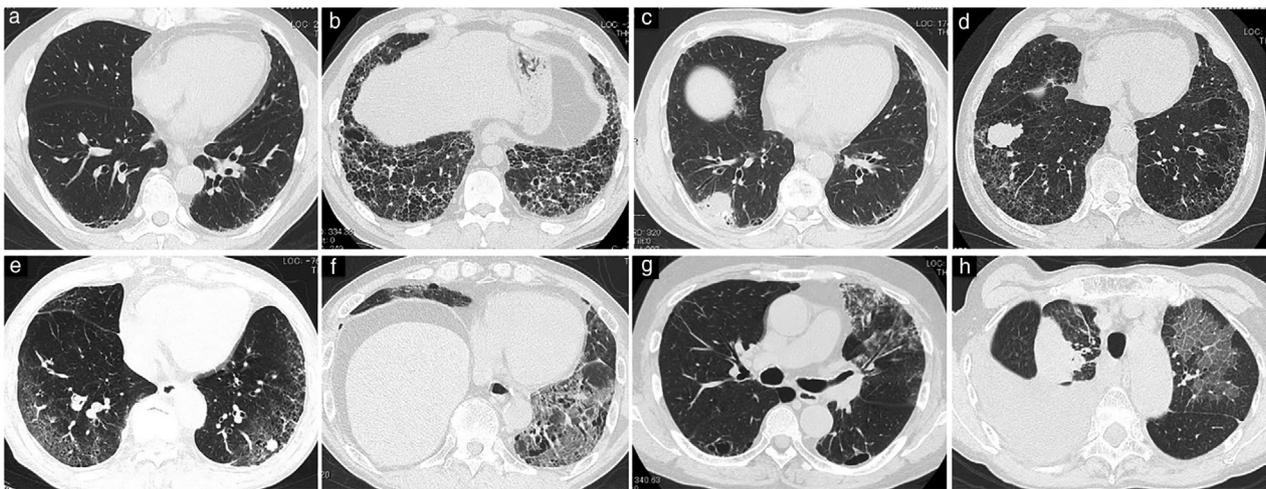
High-resolution computed tomography (HRCT) image of the chest. (a) Pretreatment chest HRCT image showing very slight reticular shading with subpleural and basal lung predominance (indeterminate for usual interstitial pneumonia [I-UIP] pattern). (b) Pretreatment chest HRCT image showing honeycomb lung with subpleural and basal lung predominance (usual interstitial pneumonia [UIP]). (c) Pretreatment chest HRCT image showing reticular lesions and traction bronchiectasis with subpleural and basal lung predominance (probable UIP). (d) Pretreatment chest HRCT image showing predominant ground-glass opacities (GGOs) with subpleural and basal lung predominance (alternative diagnosis). (e) Pretreatment chest HRCT image showing predominant GGOs with subpleural and basal lung predominance (alternative diagnosis). (f) Pretreatment chest HRCT image showing predominant GGOs with subpleural and basal lung predominance (alternative diagnosis). (g) Pretreatment chest HRCT image showing predominant GGOs with upper to middle lung field predominance (alternative diagnosis). (h) Pretreatment chest HRCT image showing predominant GGOs with perilymphatic predominance (alternative diagnosis)
